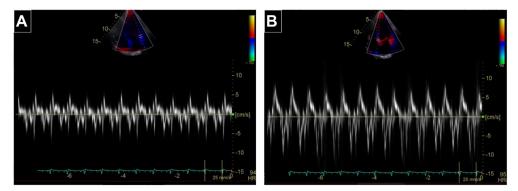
Tissue Doppler velocity analysis of medial and lateral early diastolic mitral annular velocities shows lateral e' velocity of 5 cm/ sec (A) and medial e' velocity of 10 cm/sec (B), a reversal of normal findings, known as 'annulus reversus.'
